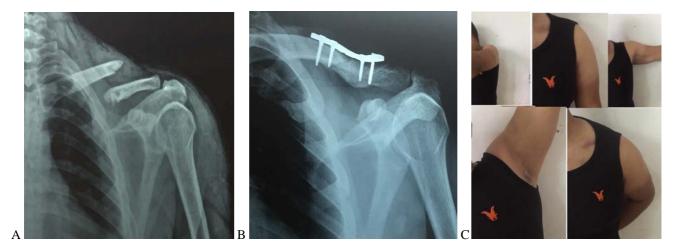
male patient, 32 years old; A: Pre-operative X-ray; B: Full union after 12 weeks; C: 12 weeks follow-up range of motion.
